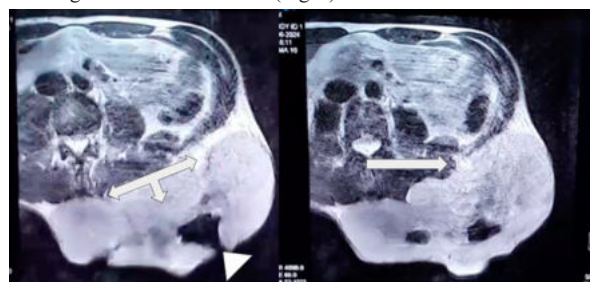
MRI showing (a) Multiple lobulations (arrow) with cavitation (arrowhead) (b) Suspicious loss of fat planes
